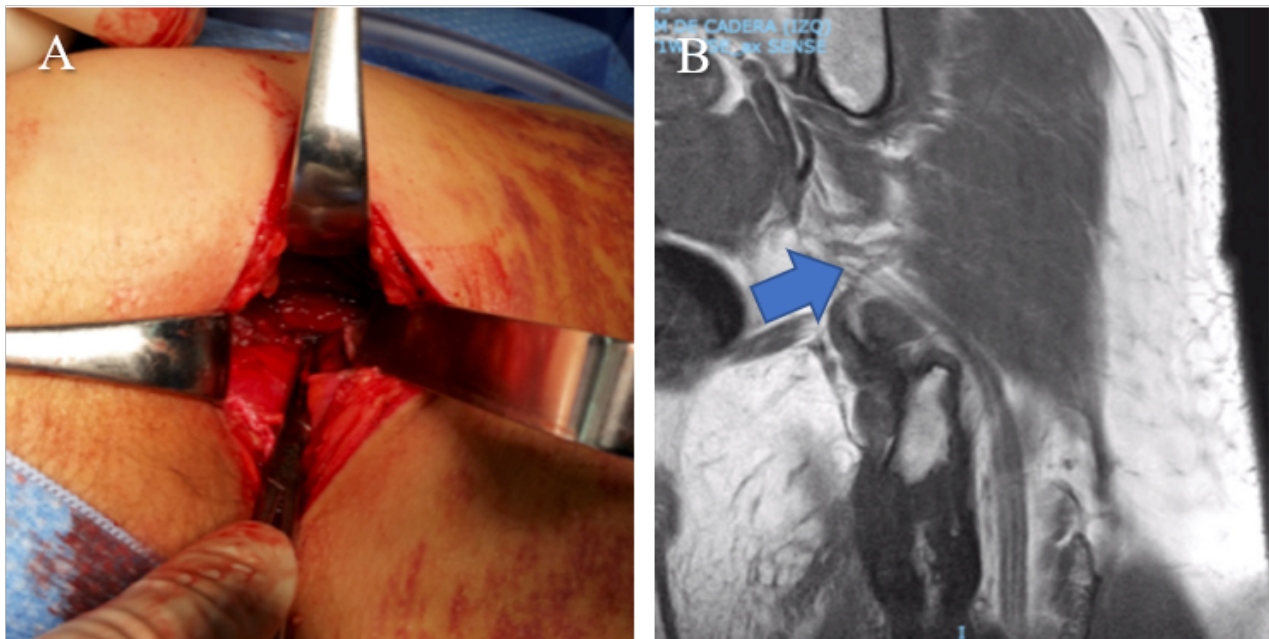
(A) Complete acute proximal hamstring rupture (Wood 5a) in a 24-year-old male. (B) T1 sagittal MRI showing complete proximal hamstring rupture [blue arrow] in the same patient (Wood 5a).
